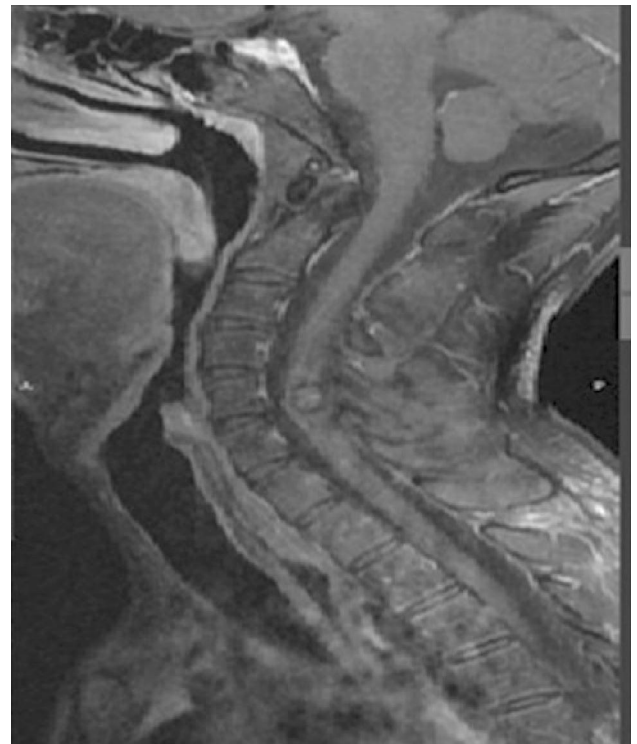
Post contrast T1-weighted image of cervical spine shows no significant enhancement of intramedullary mass
